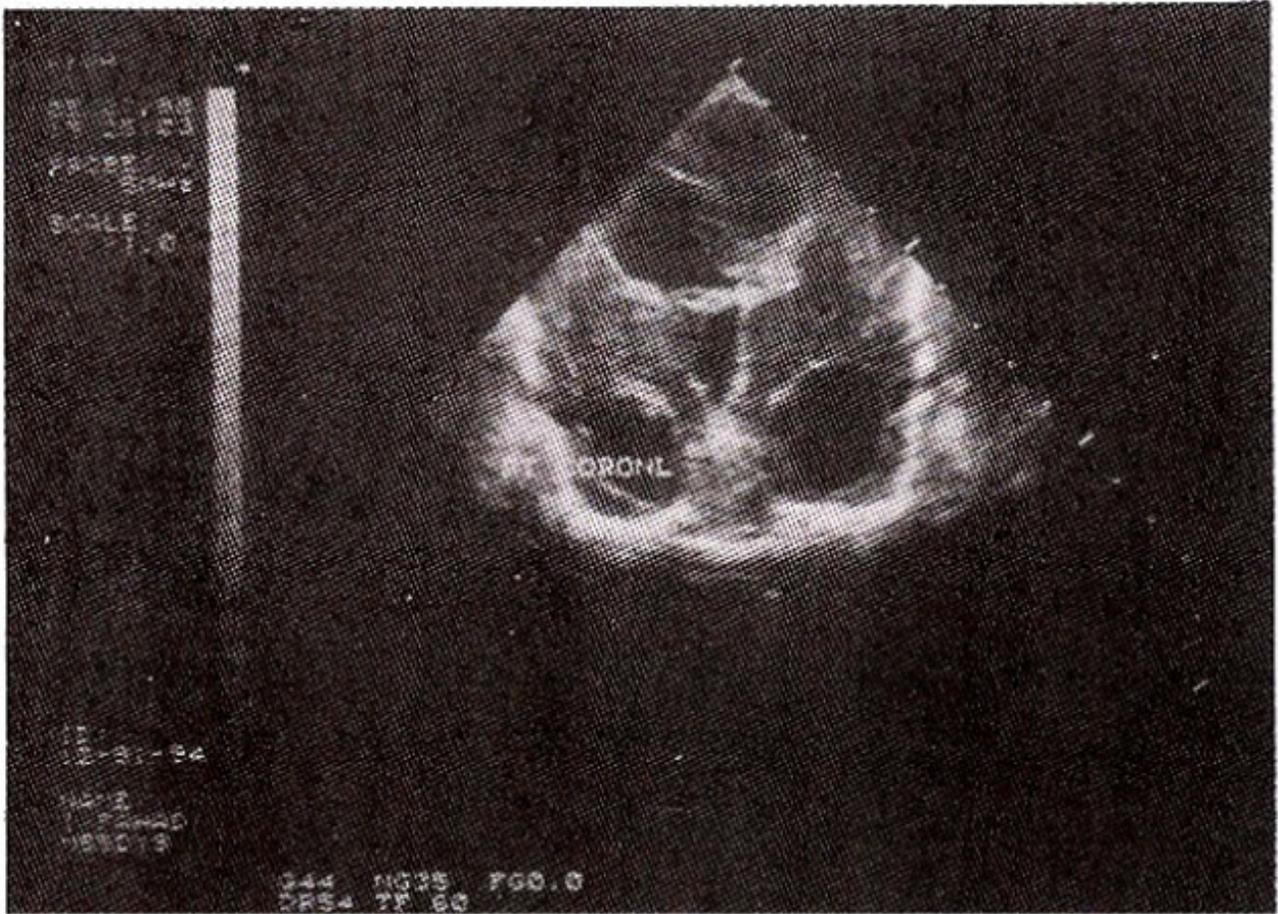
Cranial ultrasonogram showing GMH with intra- parenchymal and intra-ventricular extension. Third and lateral ventricles are dilated.
